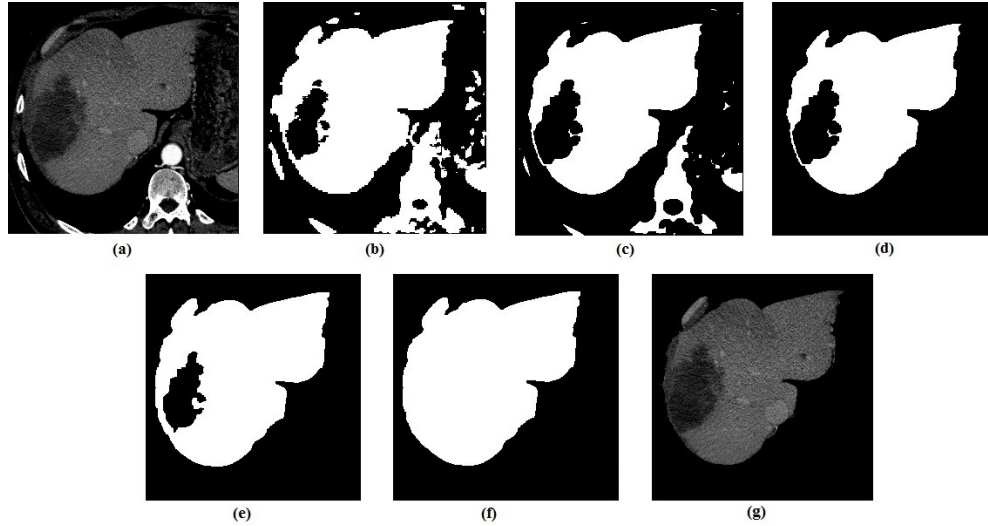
Steps of liver segmentation process. (a) The original input CT image. (b) The initial binary liver mask. (c) Operates erosion morphology. (d) Select the largest connected pixels as the liver is the largest organ that appear in CT image. (e) Operates dilation morphology. (f) The final liver mask after filling the holes. (g) The final result of the liver segmentation.
